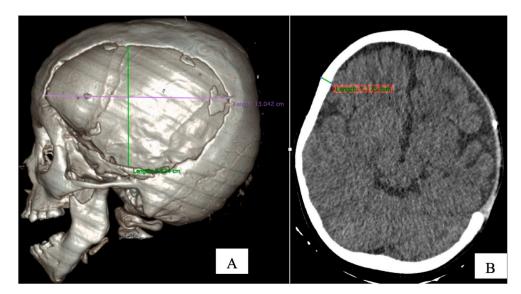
Pre-operative computed tomography. (A) A skull defect on the left front-temporo-parietal with a size of 13 cm \times 8.5 cm. (B) The thickness of diploe was 7.1 cm.
